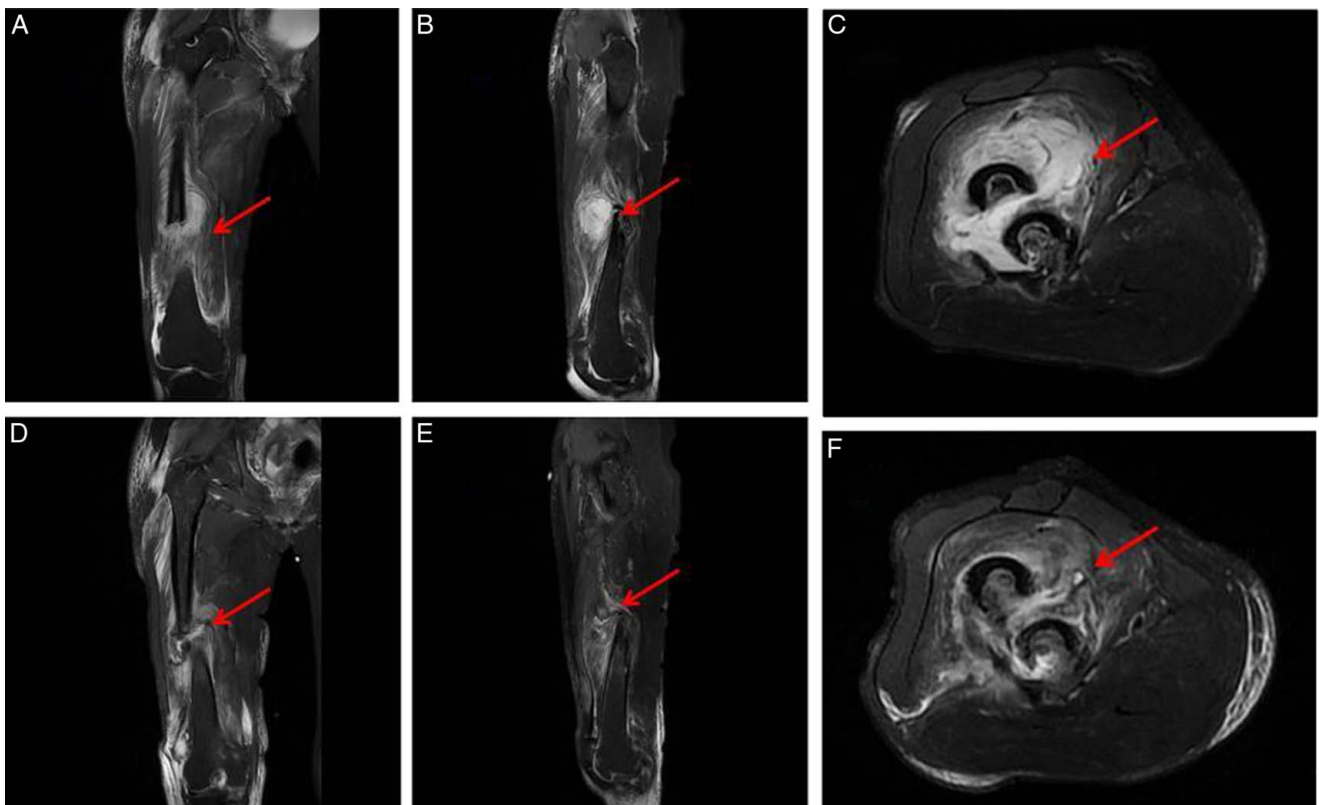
(A–C) are MRI examinations before high-intensity focused ultrasound (HIFU) treatment. (D–F) are the images of MRI re-examination after HIFU treatment.
